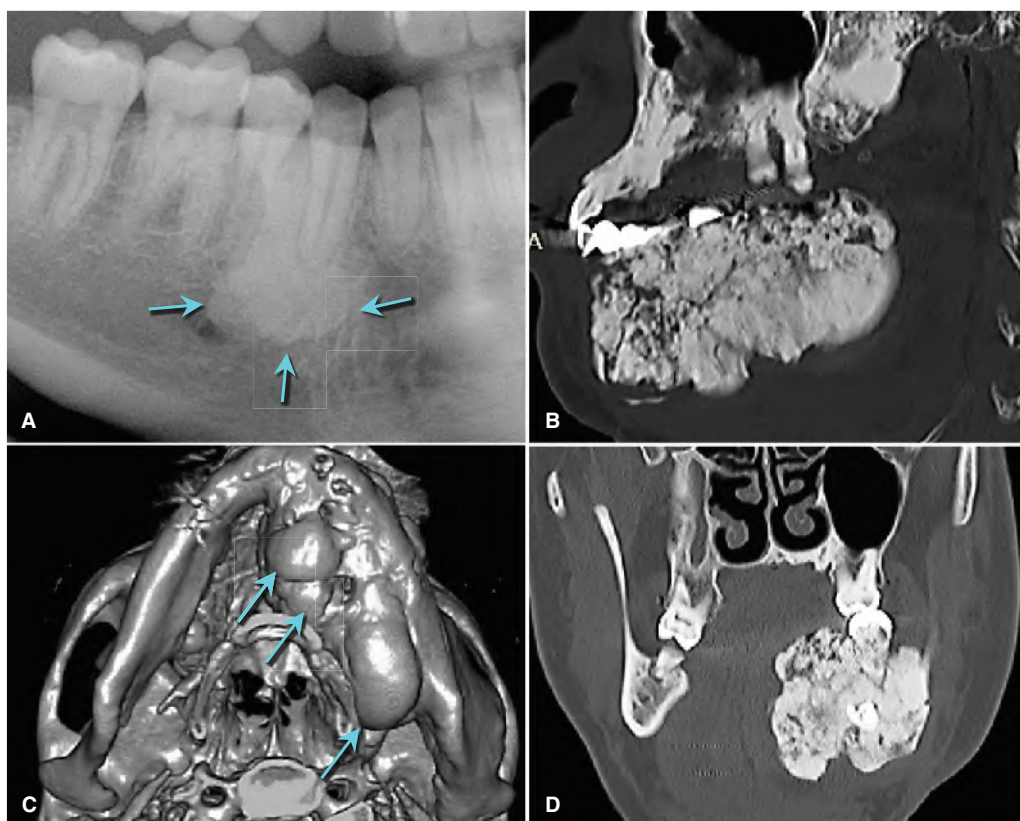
A. Panoramic radiographic section demonstrating a case of *idiopathic osteosclerosis* (blue arrows). B. CBCT reconstructions demonstrate a case of *fibrous dysplasia* (polyostotic); coronal view. C. Volumetric 3-D reconstructions. Blue arrows highlight the significant mandibular involvement and growth. D. CBCT Sagittal view. (Courtesy of Dr. Parish P. Sedghizadeh, Los Angeles, CA.)
